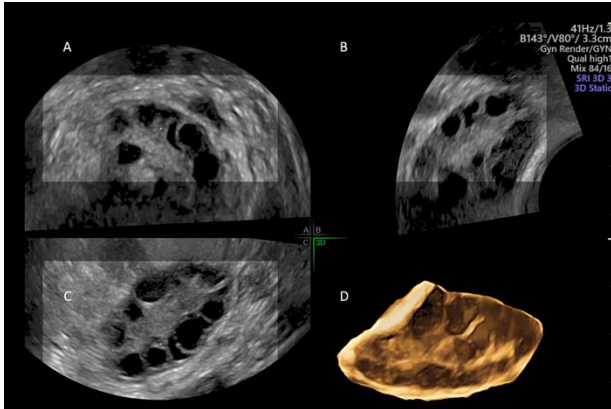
Ovarian volume assessment; 2D ultrasound shows multiple, small, follicles arranged peripherally. (A) Ovarian volume is assessed in three perpendicular planes. The software calculates (B and C) 3D ovarian structure, placement of follicles, and total ovarian volume (D) for accurate evaluation and follow-up.
